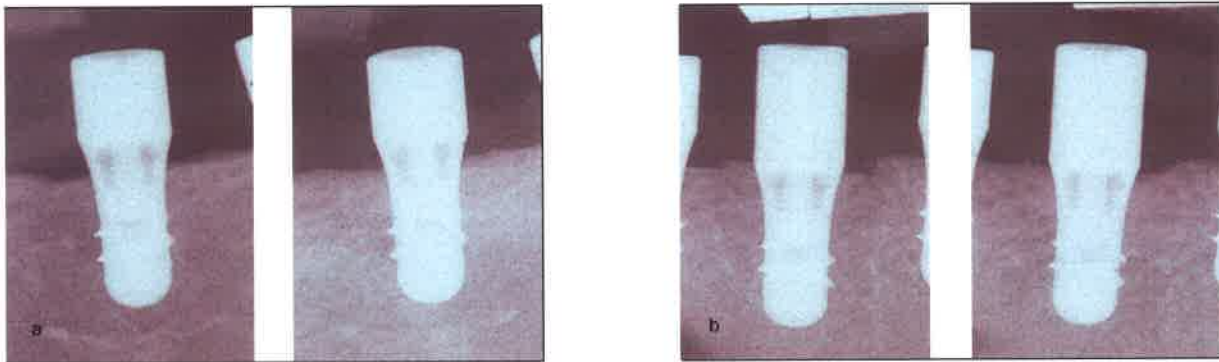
Radiographic changes from the BI to the fBIC from baseline to 6 months for (a) type A implants and (b) type F implants.
